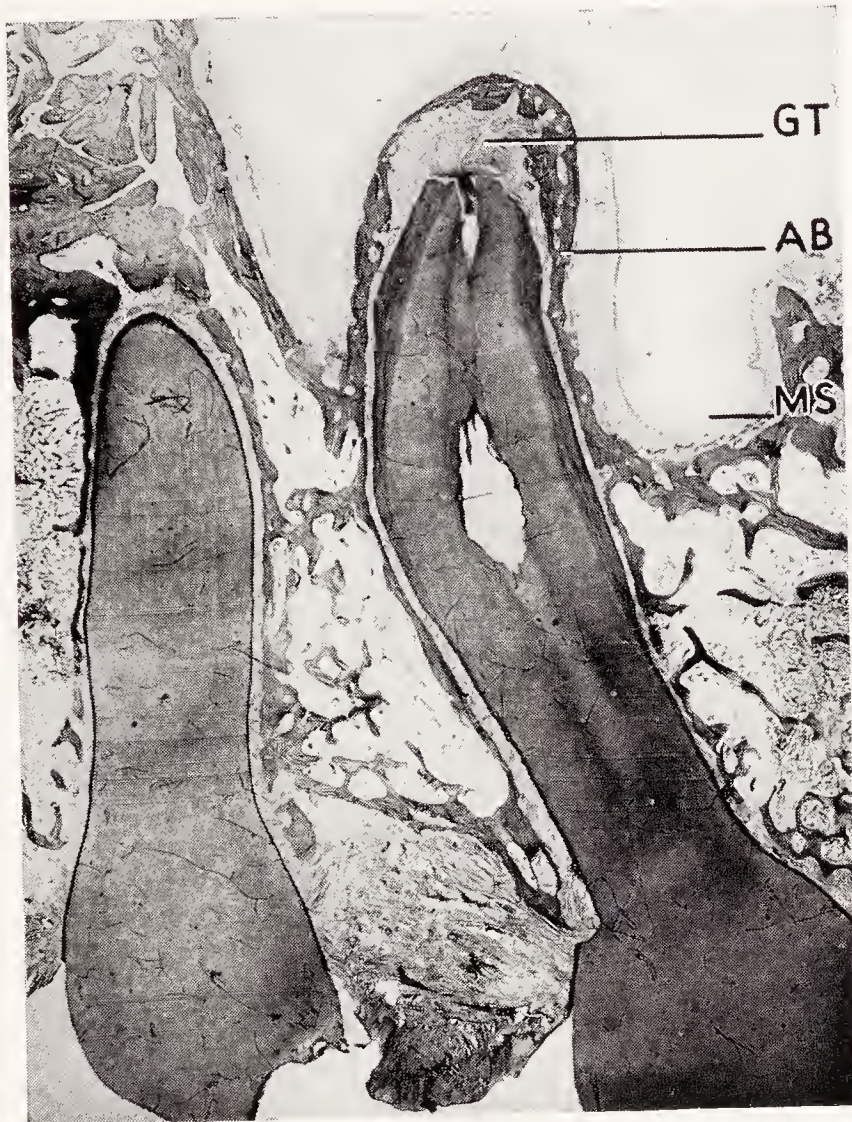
Relationship between periapical infection and maxillary sinus. Mesio-distal section through the lingual root of an upper second molar with decomposed, infected pulp. The apical foramen of this root is located about 4 mm. above the deepest point of the maxillary sinus, *MS*. *GT*, granulation tissue at the root end; *AB*, alveolar bone prominent over the floor of the maxillary sinus. The mucosa of the maxillary sinus is intact.
